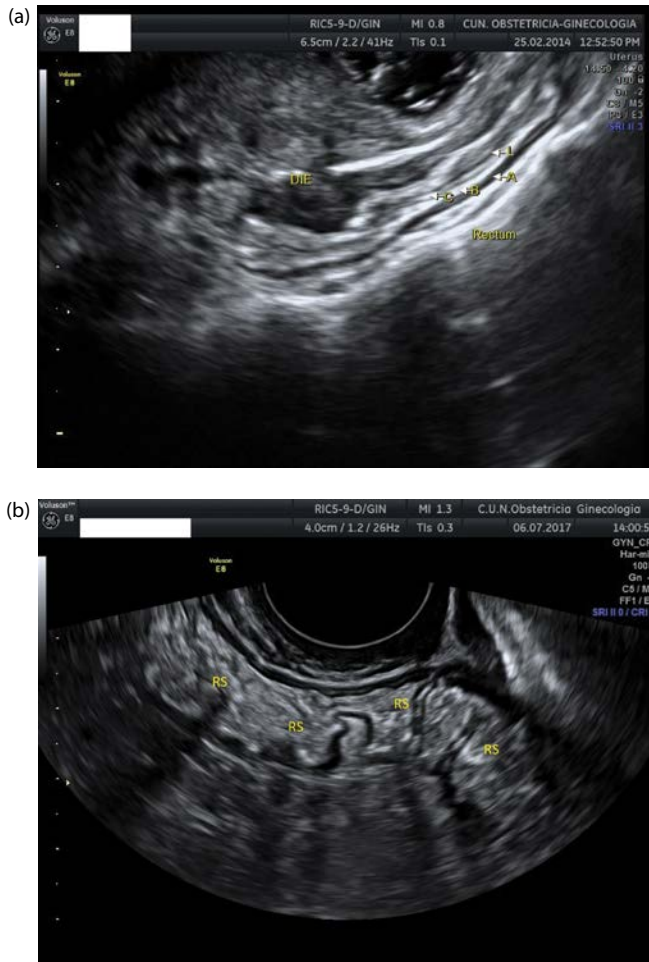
(a) Transvaginal ultrasound depicting the recto-sigmoid colon. The layers of recto-sigmoid can be visualized (A, muscularis propria; B, submucosa; C, mucosa; L, lumen). A deep infiltrating endometriosis (DIE) is observed. (b) The recto-sigmoid (RS) is seen as a snaky structure.
